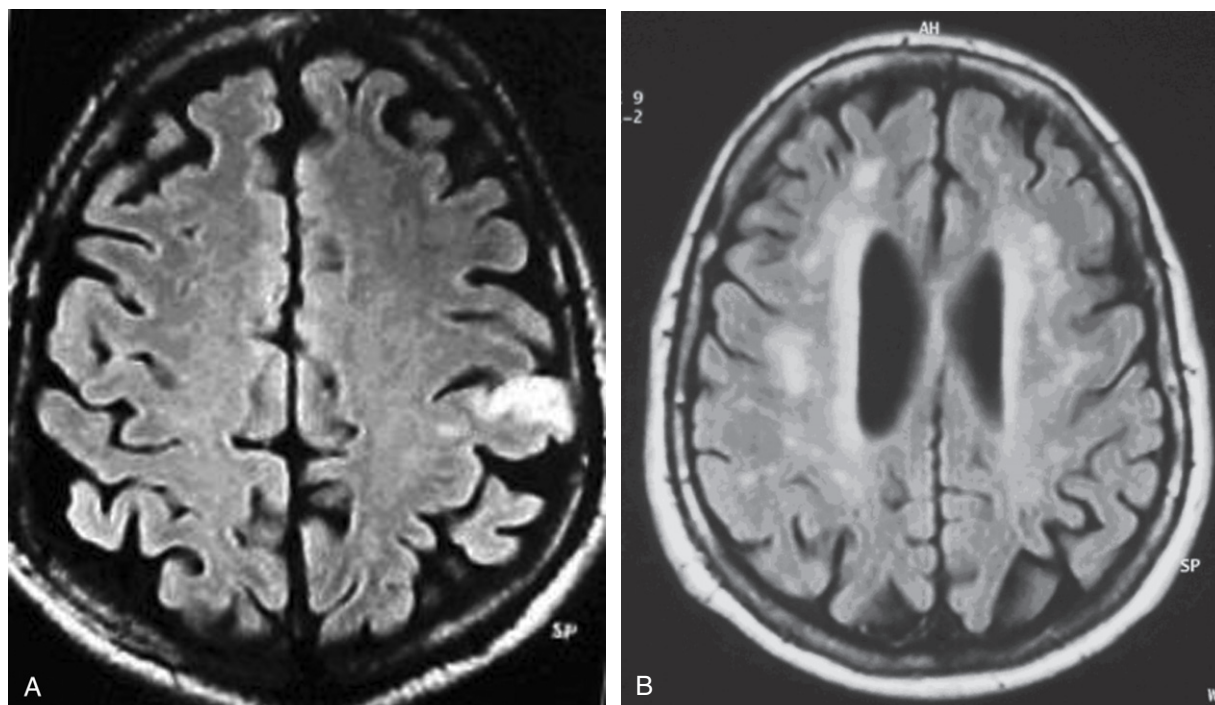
(A) Brain magnetic resonance imaging (MRI) showing a cortical area of increased signal on fluid-attenuated inversion recovery (FLAIR) sequences indicating ischemic stroke. (Courtesy of Professor Stefano Bastianello.) (B) Brain MRI showing subcortical areas of increased signal on FLAIR sequences indicating confluent ischemic lacunar and periventricular white-matter lesions. (Courtesy of Professor Stefano Bastianello.)
